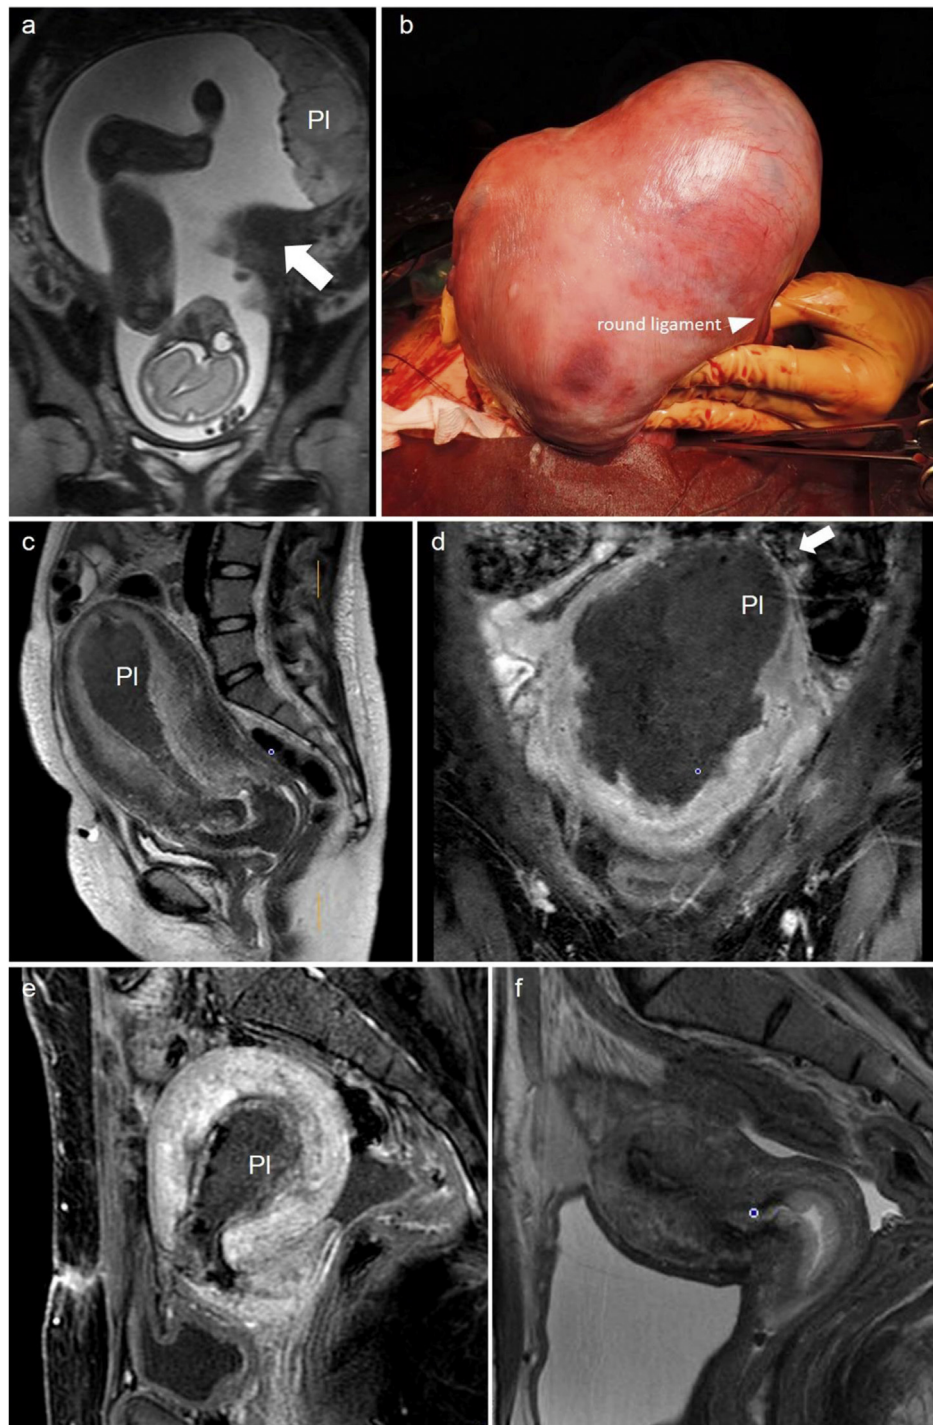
MRI images and photograph at surgery of Case 2. a) Coronal T2-weighted image showing the placenta on the left angle of the uterus. Although asymmetrical enlargement of the uterus was not apparent, we observed an atypical retraction of the uterine myometrium (arrow). A fetus in the uterine corpus. b) Left anterior view of the uterus after fetal delivery showing a left angular bulge containing the adherent placenta. Sagittal T2-weighted image (c) and coronal gadolinium-enhanced T1-weighted image (d) showing a large residual placenta on the left uterine angle and the thin myometrium on that region (arrow). The placenta is weakly but diffusely enhanced. e) A sagittal gadolinium-enhanced T1-weighted image on POD 39. The placenta has been decreased in size and only its periphery is enhanced. f) A sagittal T2-weighted image on POD 136. The placenta has disappeared almost completely. PI; placenta.
